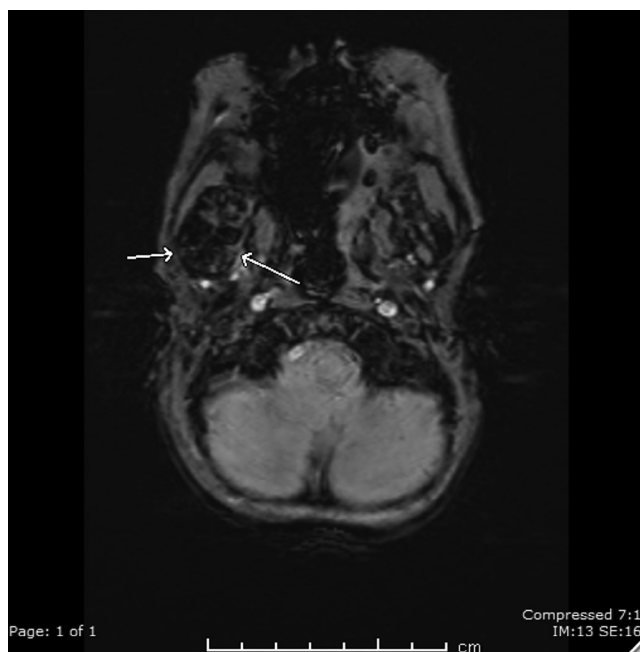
Axial susceptibility weighted image shows presence of blooming artifact within the mandibular soft tissue mass, corresponding to calcifications seen on computed tomography.
